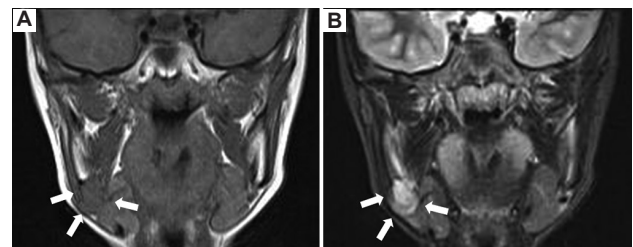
Magnetic resonance imaging. (A) T1-weighted image (axial plane). (B) T2-weighted short inversion time inversion-recovery image (axial plane). T1-weighted image showed a low signal intensity (arrows), and T2-weighted image showed a high signal intensity with a partially irregular border with the surrounding bone (arrows).
